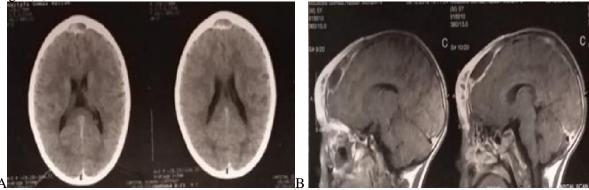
shows: A- CT brain axial view shows signs of infection with bone erosion. B. MRI sagittal view shows thinning of bone, edema of bone marrow, enhancement of dura with sub dural collection.
